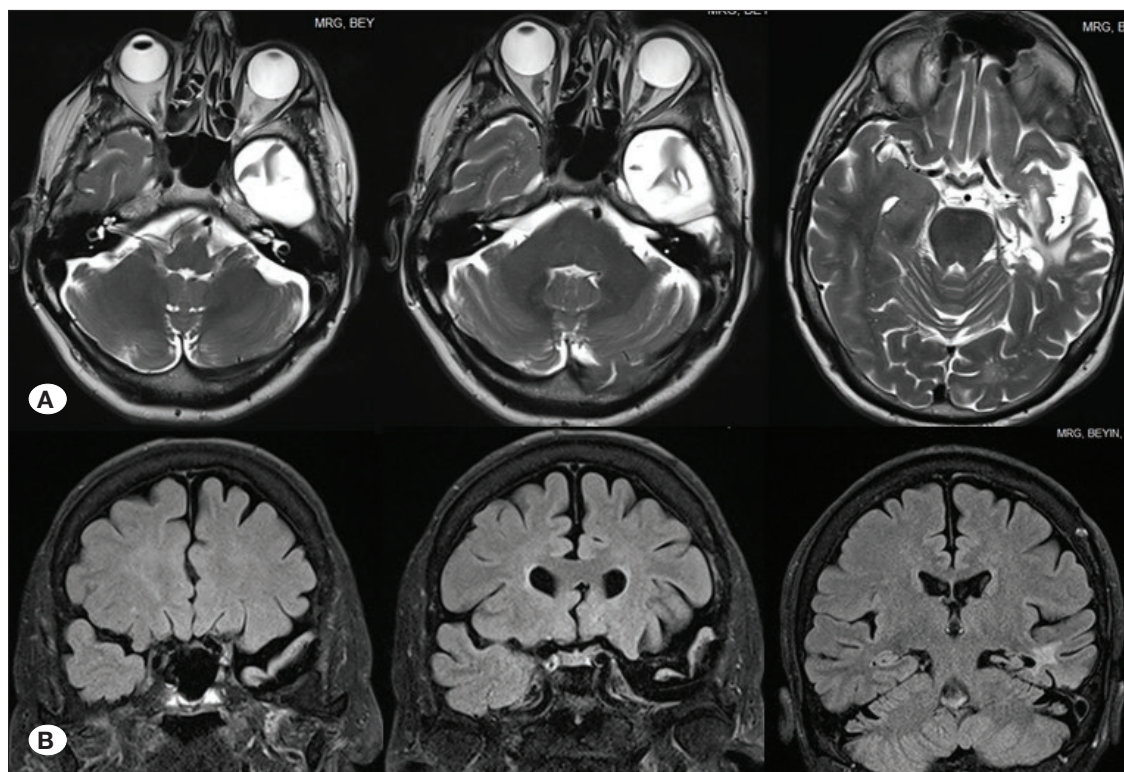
A) Preoperative axial T2-weighted magnetic resonance imaging (MRI) sections of patient #6; B) Preoperative T1-weighted coronal MRI sections of patient #6.
